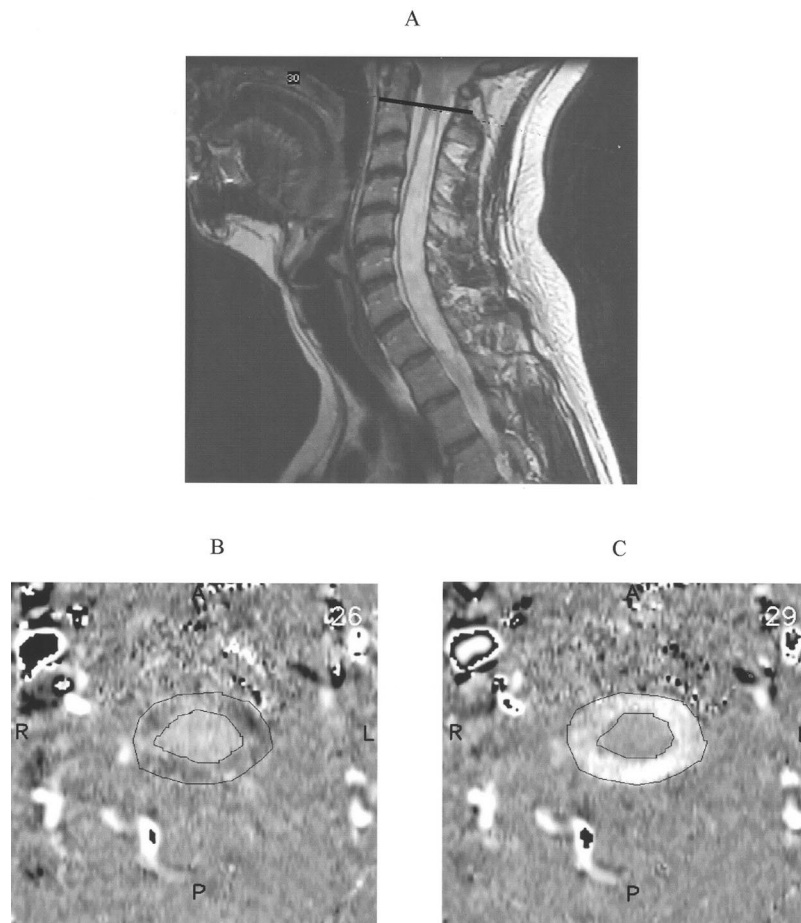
Midsagittal anatomy and the axial encoded images before decompression. A, Midsagittal T2-weighted MRI before decompression show that the cerebellar tonsils extend approximately 1.0 cm below the foramen magnum, and a large fluid-filled central canal of the spinal cord extends throughout the cervical and thoracic spine. The line drawn through the region of interest above the syrinx indicates the plane where the subsequent phase-contrast axial images were taken. B, Phase-contrast axial MRI during early systole. The downward movement of the spinal cord is shown by the white pixels throughout the inner circle region. The black pixels depict spinal-to-cranial CSF flow. The pixel intensity is proportional to the velocity of flow through the region of interest. Note that no syrinx is visualized in this region of the spinal cord. C, Phase-contrast axial MRI during mid systole. The white pixels inside the outlined region of interest depict cranial-to-spinal CSF flow through the subarachnoid space. Note that the downward movement of the spinal cord occurs in early systole, while the peak of CSF flow through the subarachnoid space takes place in mid systole.
